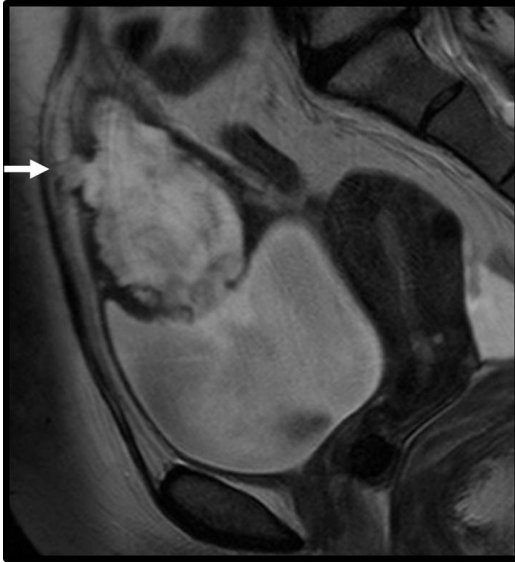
Sagittal T2-weighted image showing mixed signal intensity mass in the dome extending into the urachal remnant and anterior abdominal wall (*arrow*).
